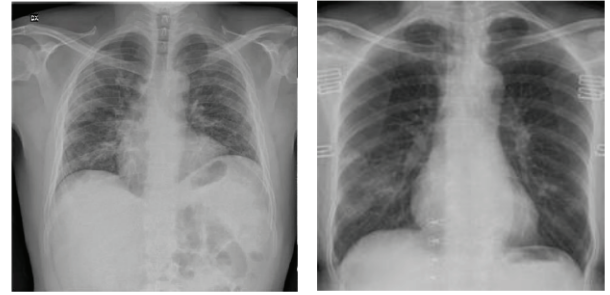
Representative chest X-ray images of COVID-19 patients.
